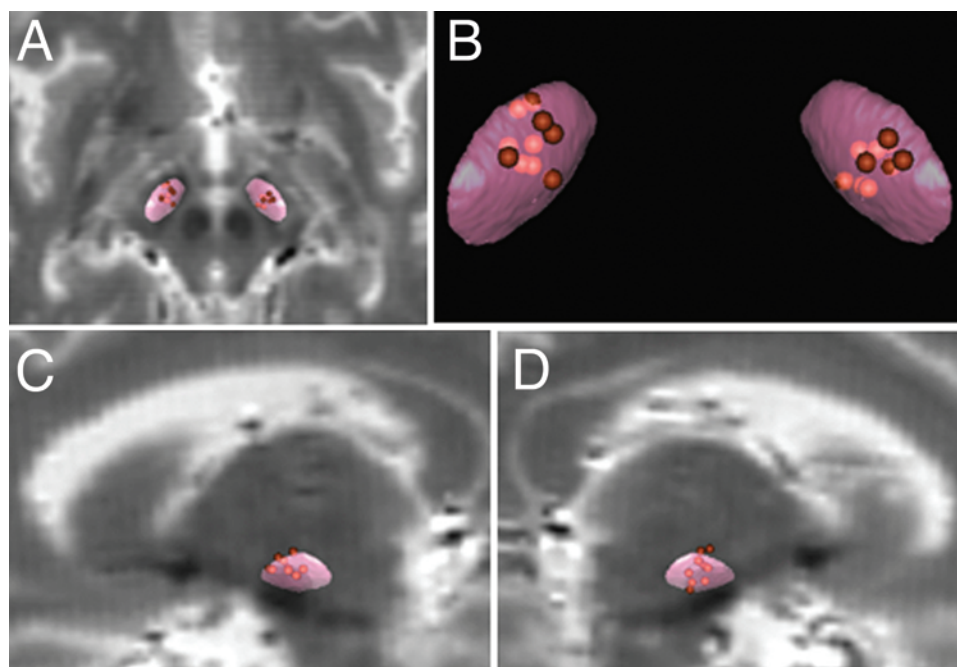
Contact localization in the series of 10 patients with PD treated by STN DBS. The 20 contacts (10 on each side represented as *spheres*) were back-projected onto the atlas. A: The 2 STN (*pink*) are seen with an axial section of the T2-weighted MR images of the atlas. B: Closer view of the same STN. Contacts localized outside the STN are *dark colored*; those within the STN are *light colored*. C and D: Sagittal views of left and right STN with T2-weighted MR images of the atlas.
